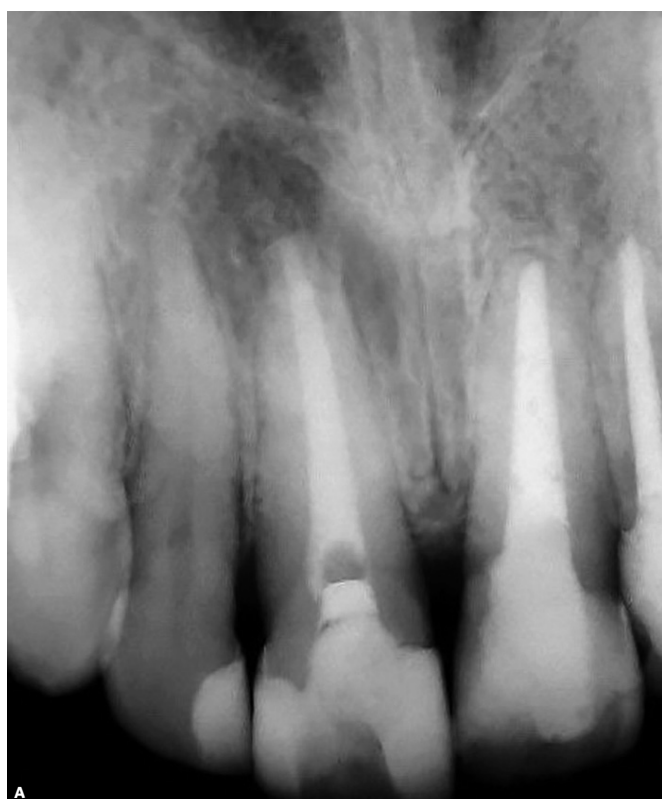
Control radiographs: A) 60 days; B) 120 days.
